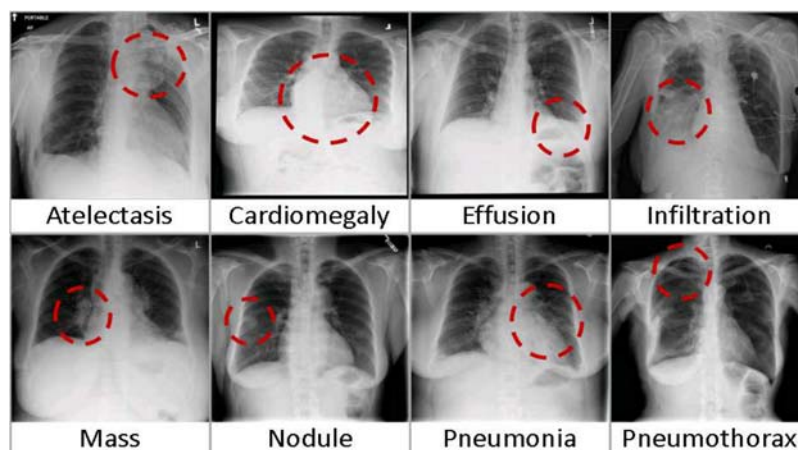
Chest X-ray8 dataset with 8 common thoracic disease labels
